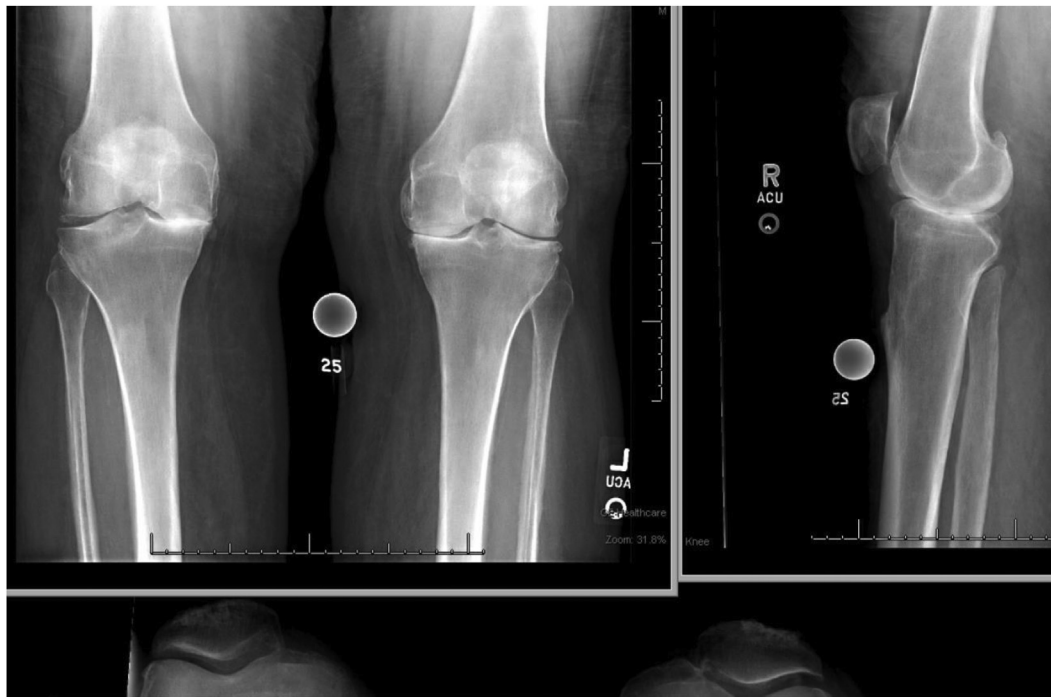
Preoperative x-rays demonstrating tricompartamental osteoarthritis more pronounced in the right knee than the left knee.
